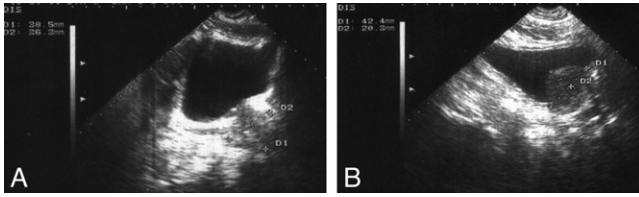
Sagittal suprapubic ultrasound shows 2 prostates with similar volume but with no intravesical protrusion (A) and with 20 mm lateral lobe protrusion (B).
